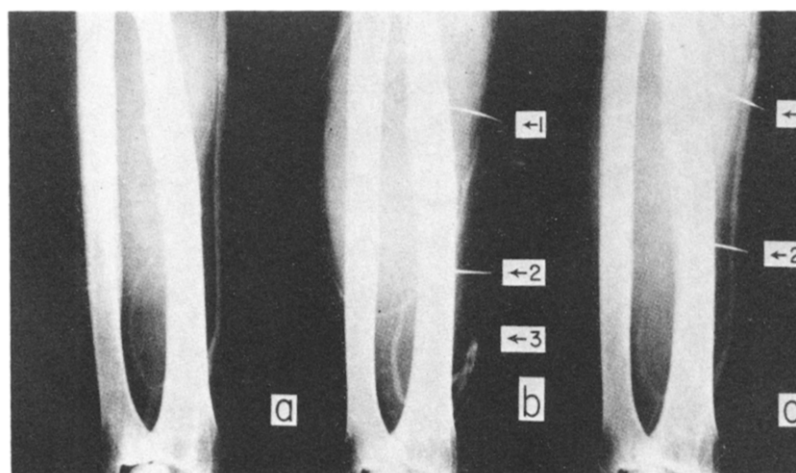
Radiographic demonstration of the lysis of an experimentally induced clot in a human volunteer. Panel a, control venogram before the induction of the clot showing a patent vessel. Panel b, venogram taken 24 h after the induction of a clot by traumatizing the intima of an antecubital vein by a dental burr inserted through a needle. The radioopaque lines at 1 and 2 were made by nichrome wires on the skin surface to define the extent of the clot; the arrow at 3 indicates the distal portion of the clot. Panel c, venogram 24 h after the streptokinase infusion, showing complete lysis of the clot without reformation. From Johnson and McCarty (22).
